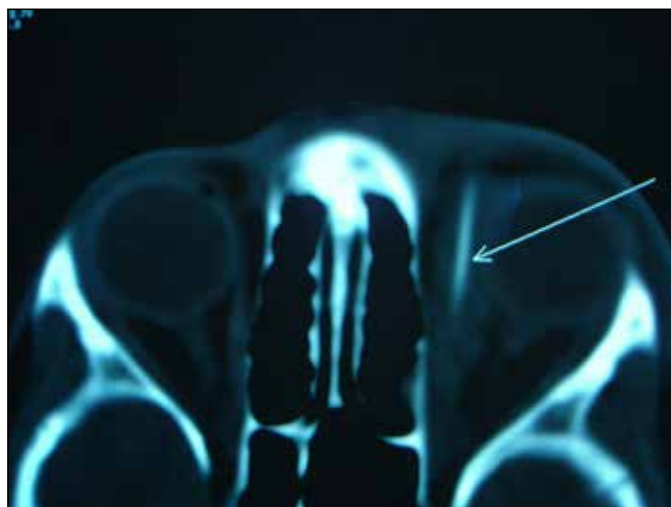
Transverse section of CT scan showing radiopaque hyperdense foreign body lodged in medial compartment of left orbit.
